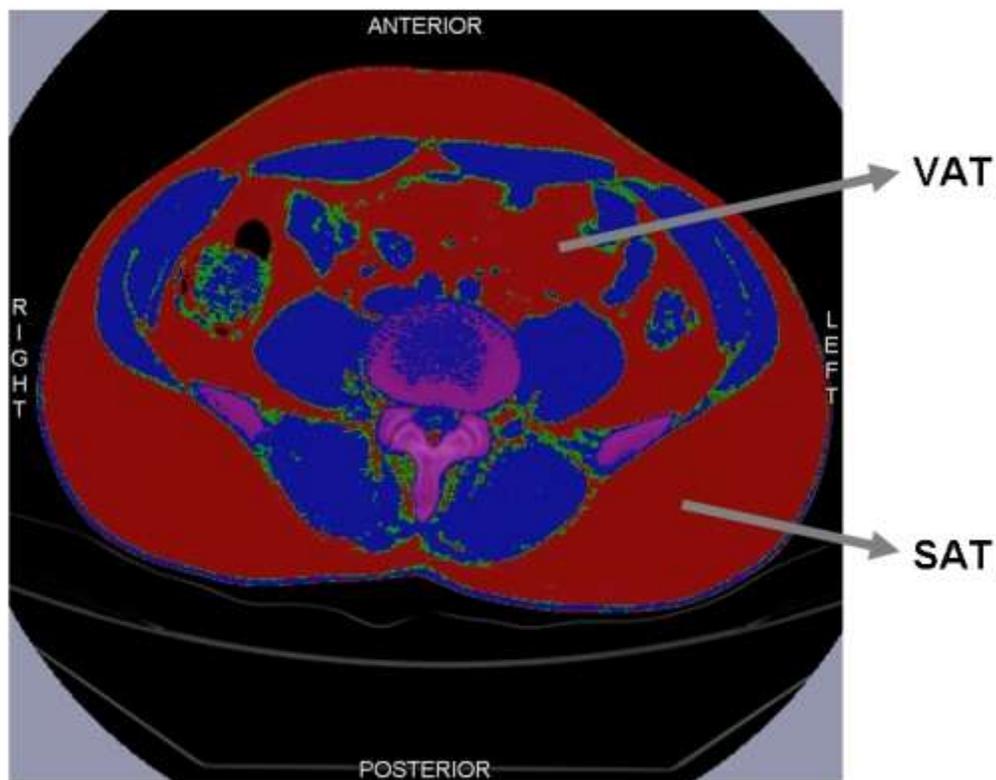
An example of study participant's CT-scan indicating the location of VAT and SAT (Image courtesy of Dr. Scott Lear).
